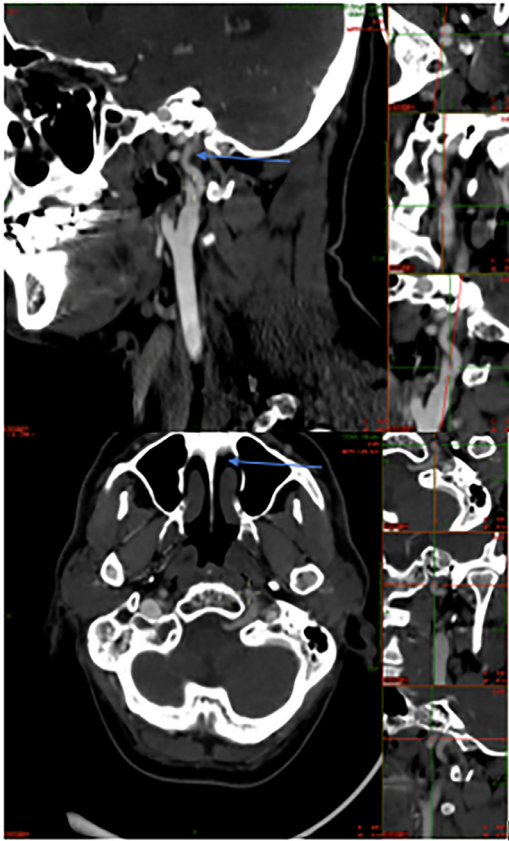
Axial and sagittal CT brain and neck angiogram shows persistent hypoglossal artery that continue as basilar artery.
